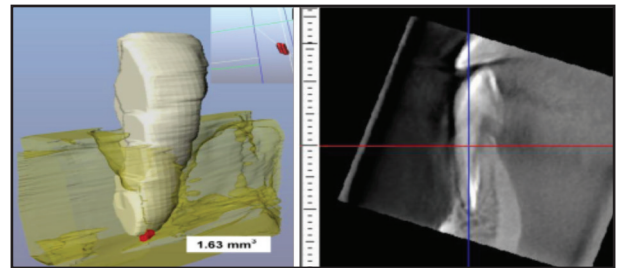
A photograph showing CBCT image of periapical lesion size in mm<sup>3</sup> of lower right lateral incisor after 6 months.
